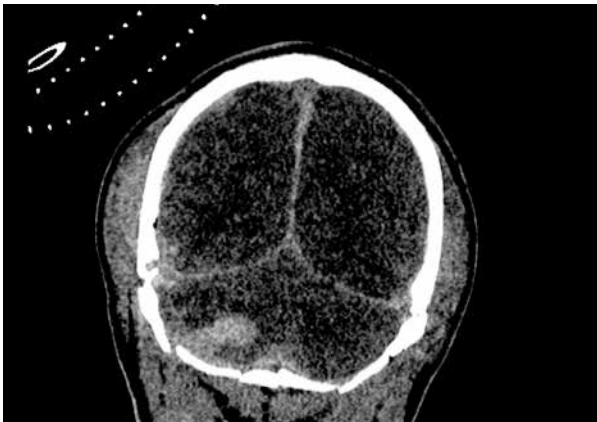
CT of the head on admission to hospital performed with a 64-slice CT Revolution EVO GE MEDICAL SYSTEMS, 120 kV, 160 mA, frontal reconstructions, slice thickness 0.625 mm. Visible are midbrain haematomas of the right hemisphere of the cerebellum, subdural haematoma along the right hemisphere of the brain and blood in the brain fissures evidence of subarachnoid bleeding. Also visible are numerous cranial bones fractures. Intracranial gas bubbles on the border of the right temporal and occipital lobe.
